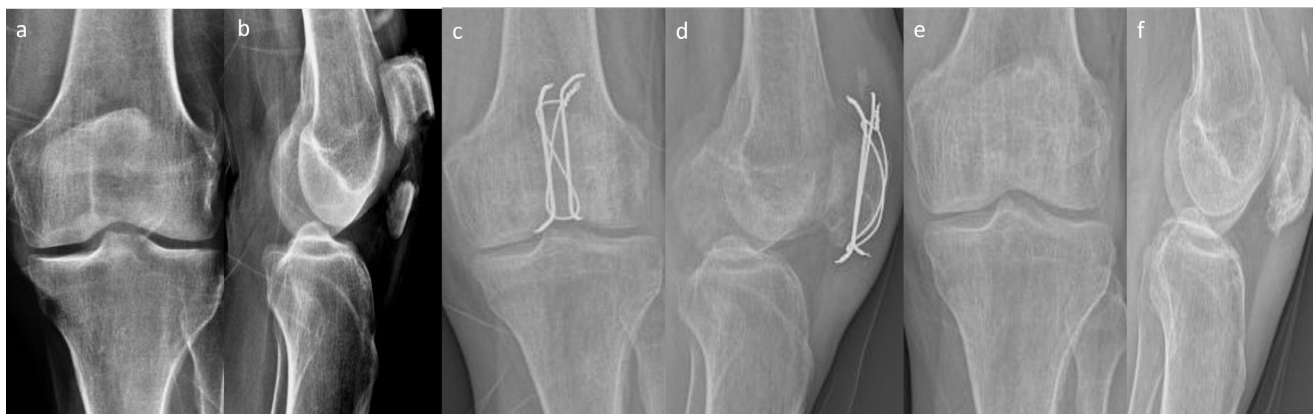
Preoperative anteroposterior (AP) and lateral (L) knee radiographs of a fifty-seven-year-old male patient who sustained an AO-34C1 patella fracture are demonstrated in a and b. Early postoperative and latest (after implant removal) AP and L knee radiographs are shown in c, d, e, and f, respectively.
